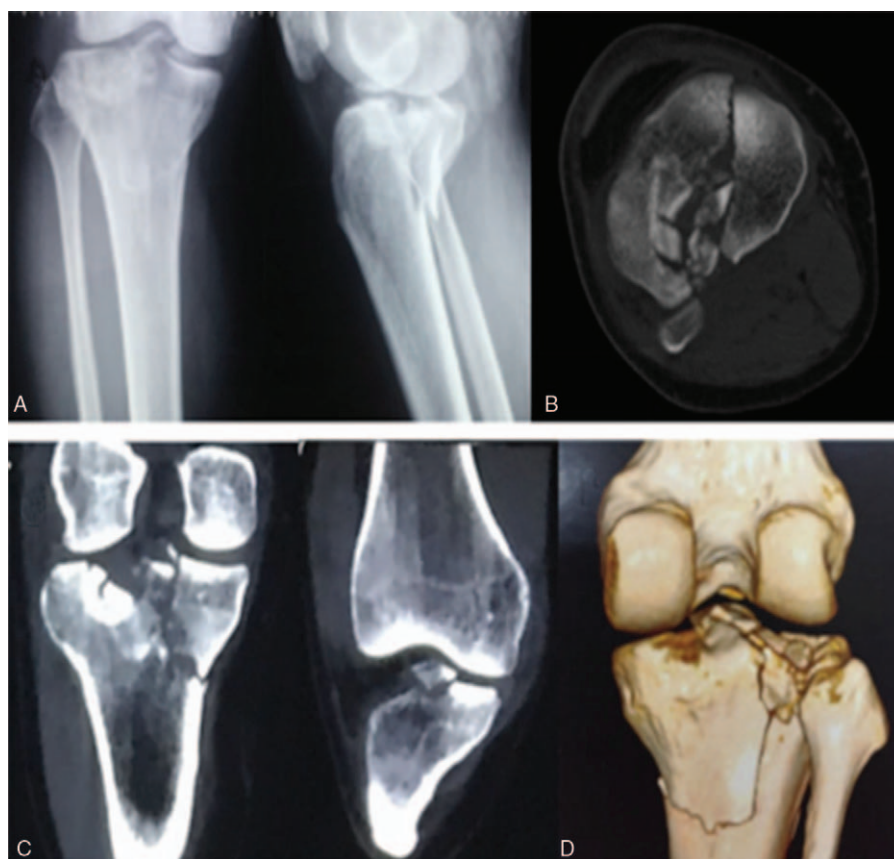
Preoperative plain radiographs and CT scans. A: AP and lateral views showing an AO type 41-B3 fracture. B: Axial CT scan showing a depressed fracture fragment of the posterolateral quadrant combined with a split fracture fragment of the posteromedial quadrant. C: Coronal CT demonstrating an avulsion fracture of the tibial intercondylar eminence. D: Reconstructed CT scan.
